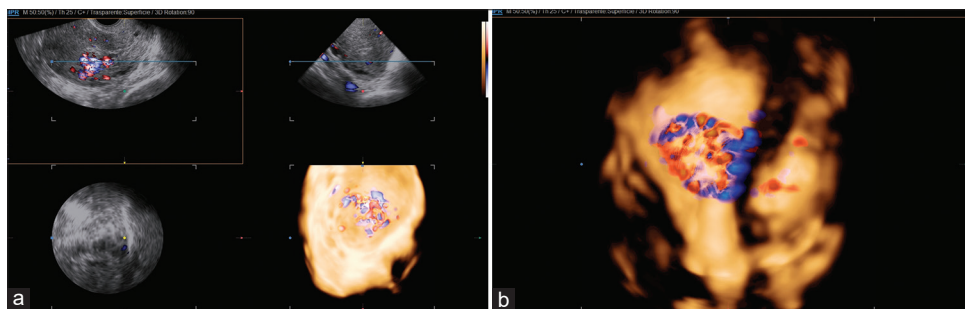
(a and b) Three-dimensional power Doppler ultrasound reconstruction of the uterus using a glass body technique to differentiate tissue and vessels. This method reveals a hypervascular lesion in the myometrium
